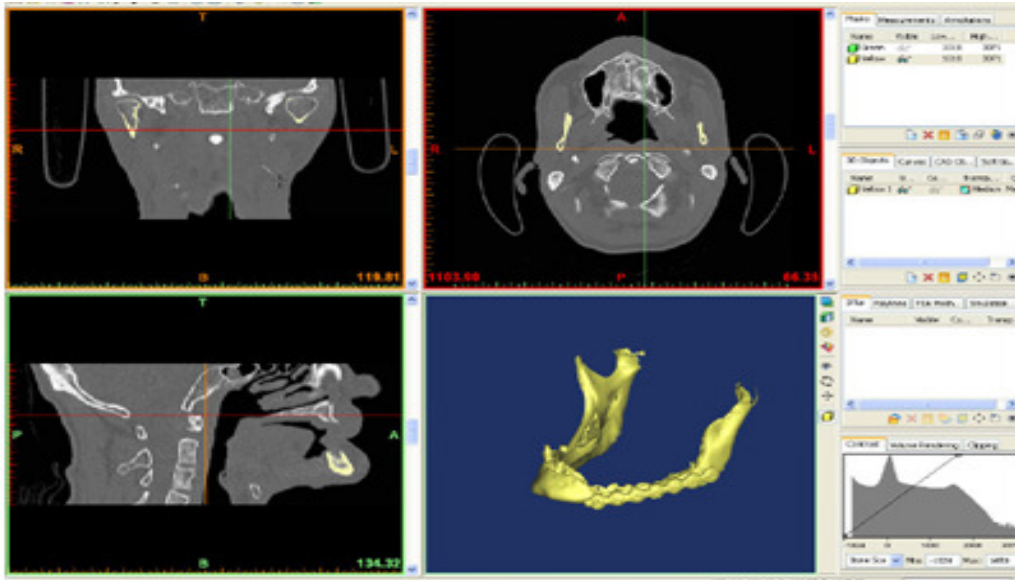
CT computation of jaw
